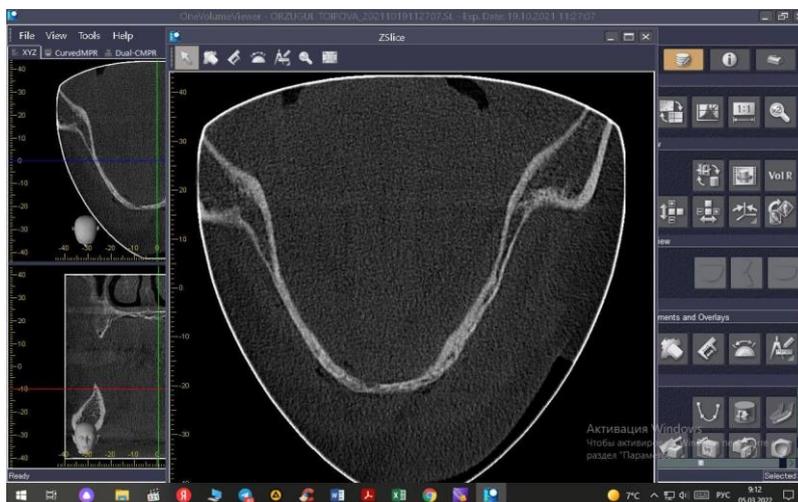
Computed tomography before implant placement
